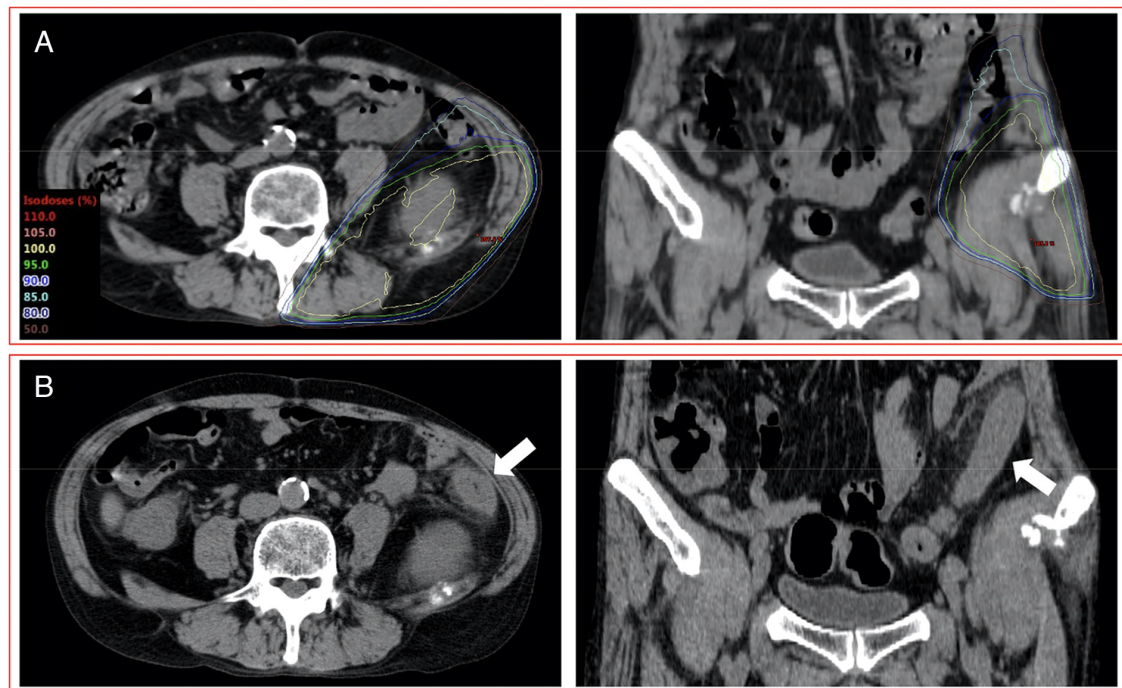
A patient (58 years, male) with grade 2 RIE after PRT involving the large bowel and administration of ICIs. (A) CT images indicating the dose distribution of PRT to an iliac bone metastasis (28.8 Gy in 8 fractions). (B) CT images acquired 17 days after the completion of PRT. This patient developed grade 2 RIE with segmental and circumferential bowel wall thickening and pericolic fat stranding in the area of the irradiated field (white arrow) as observed in CT images after combination therapy with PRT and ICIs. Left panel showed transverse images and the right panel showed coronal images. RIE, radiation-induced enterocolitis; PRT, palliative radiotherapy; ICIs, immune checkpoint inhibitors; CT, computed tomography.
